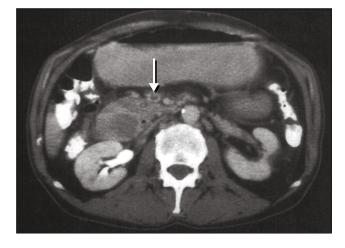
Acute Mesenteric Venous Thrombosis. Abdominal computed tomogram shows a thrombus (arrow) in the superior mesenteric vein. (Adapted from Rhee RY, Gloviczki P. Mesenteric venous thrombosis. Surg Clin North Am. 1997 Apr;77[2]:327-38. Used with permission.)
